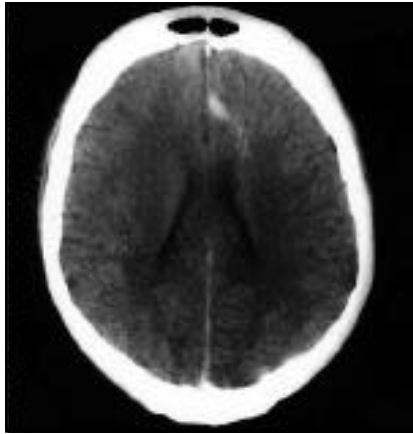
Contrasted axial CT scan of the brain at the level of lateral ventricles showing an enhancing, ill-defined left medial frontal lesion with surrounding cortical changes.
